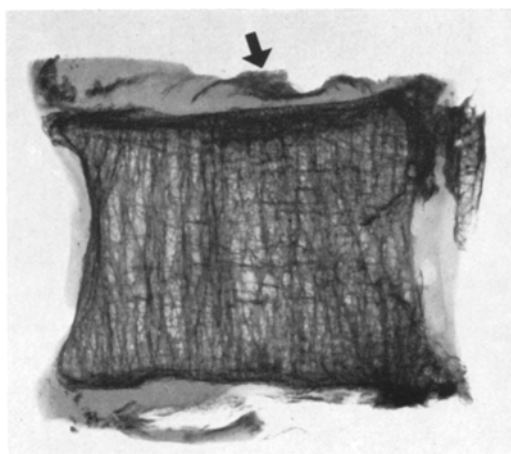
Deposition of x-ray opaque material in the intervertebral discs (arrow)
